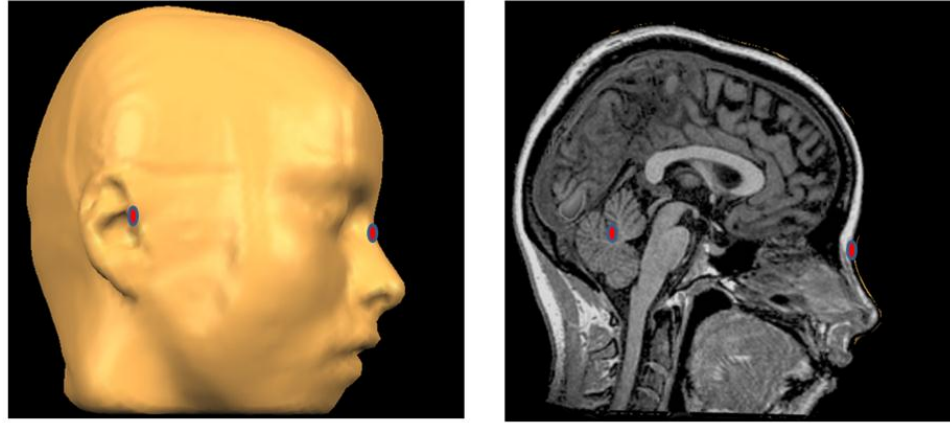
Co-referencing external landmarks to fit the MRI to the participants' skull
